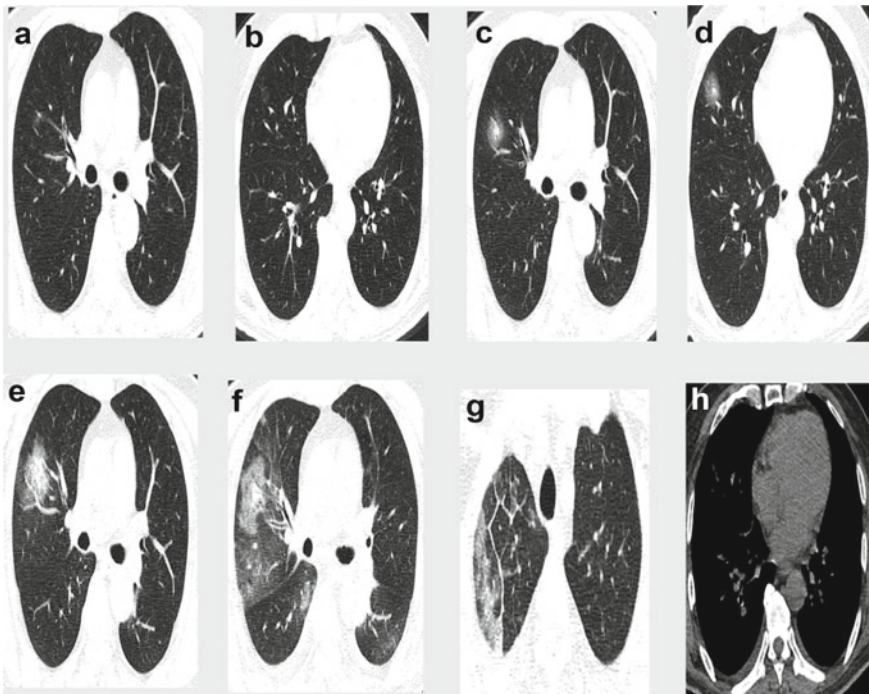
CT scan images of a suspected COVID-19 case
